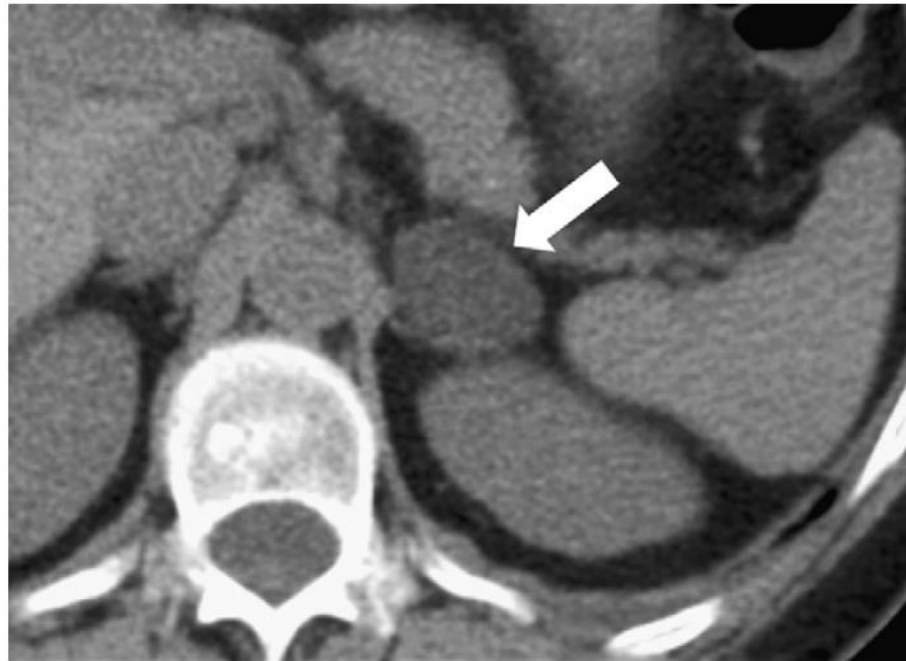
Axial, unenhanced CT image shows a lipid-rich left adrenal adenoma (arrow). The small, ovoid-shaped, well-defined tumour has a homogeneous low attenuation of approximately -0.7 HU.
